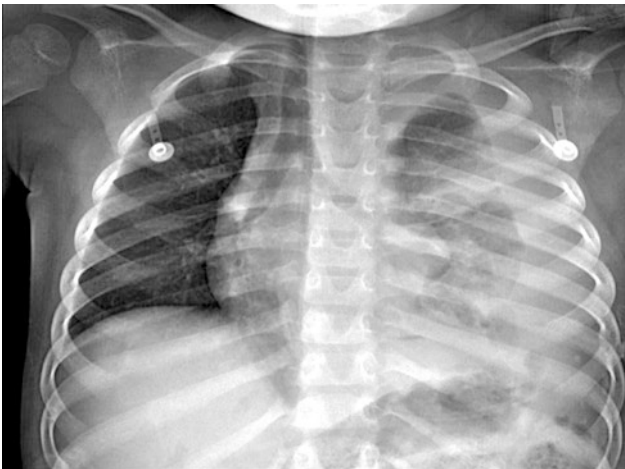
Chest radiograph of a left side tension pneumothorax with displacement of heart and mediastinum to the right. This is a clinical diagnosis and requires immediate decompression
